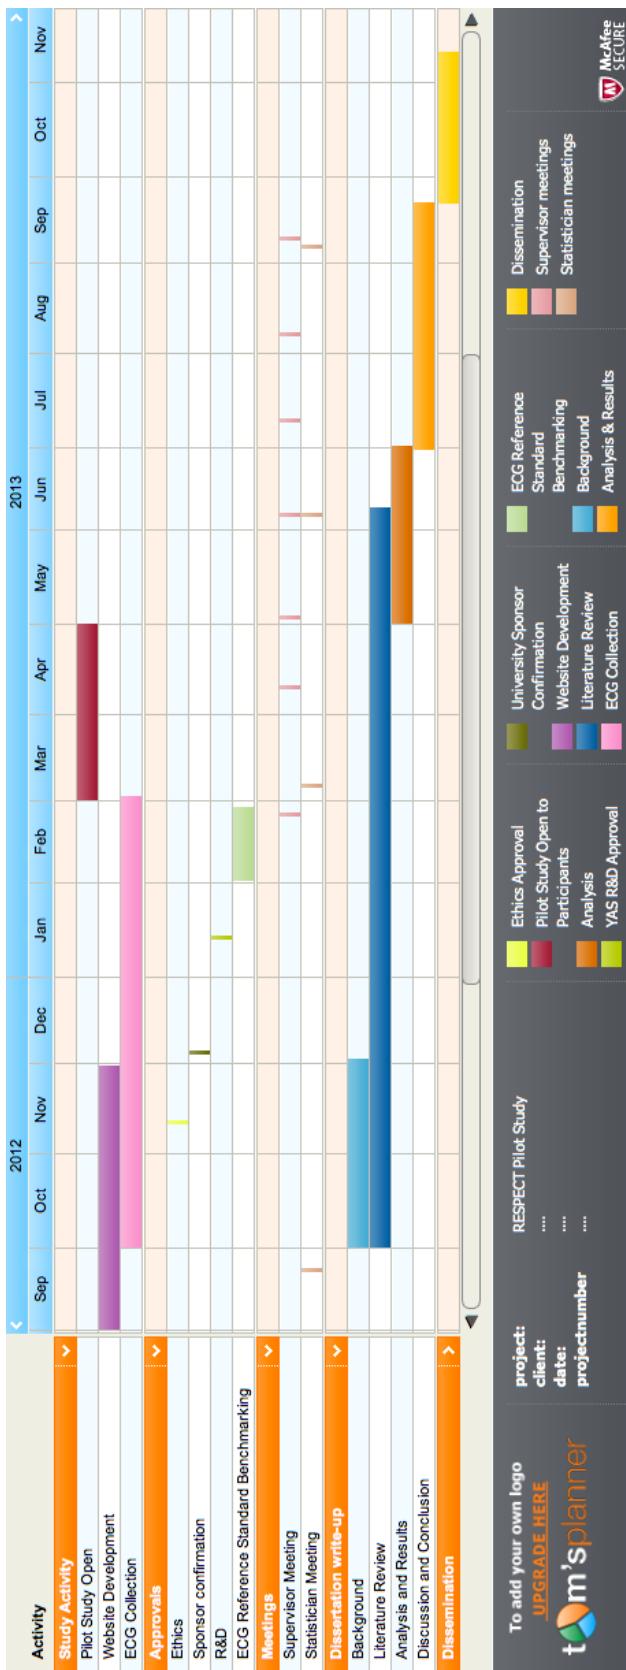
Gantt chart for RESPECT pilot study
